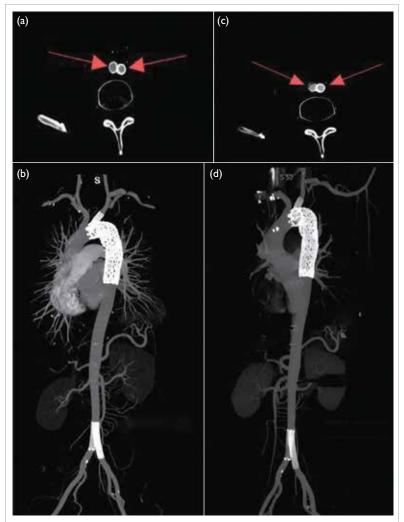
Postoperative thoracoabdominal computed tomography angiography at 6 days (a, b) [24 November 2023] and 6 months (c, d) [2 May 2024] demonstrated no stent migration, with unobstructed blood flow within the stent and vessels, and kissing stents in the iliac arteries (arrows in [a] and [c])
